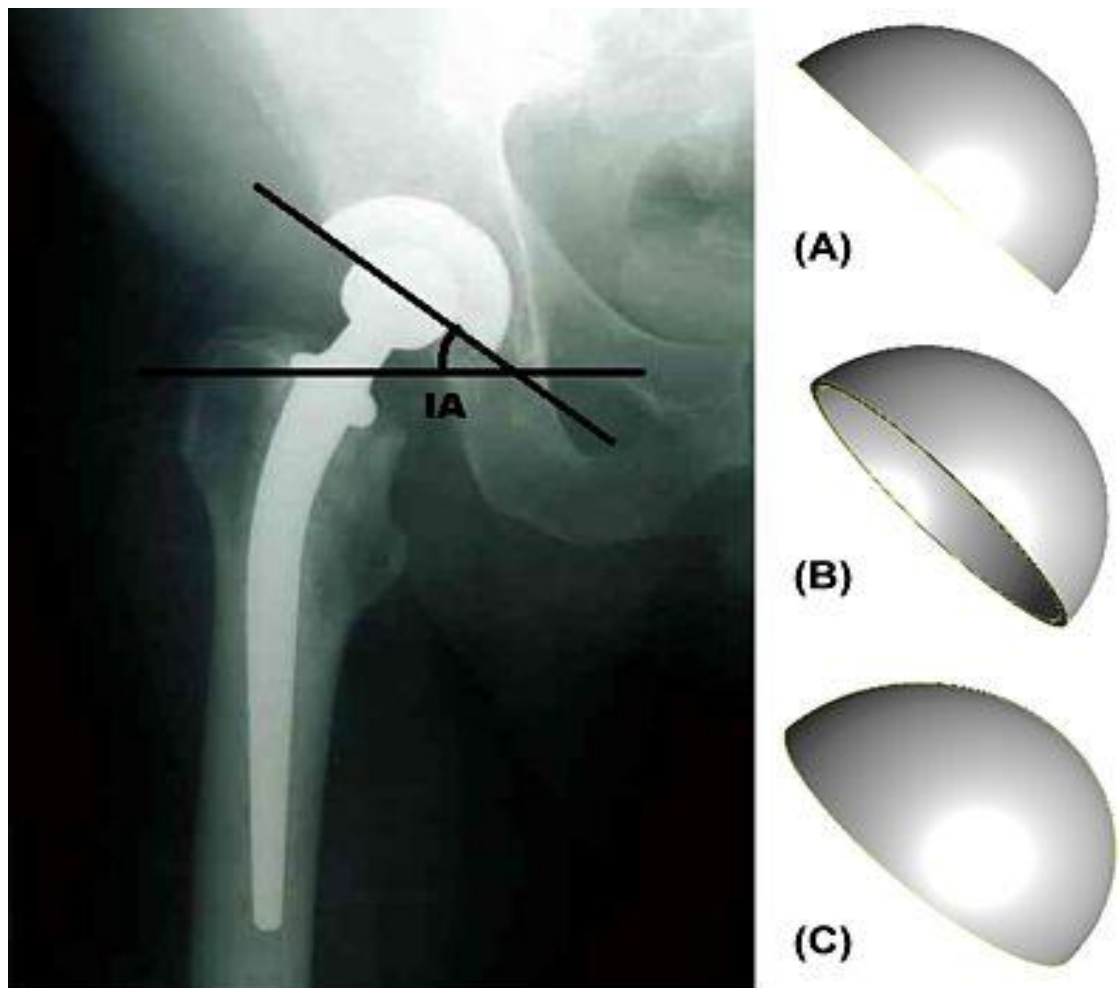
Left: Radiographic image of a right-side THR prosthesis, with the inclination angle (IA) marked. Right: Model of a right-side acetabular cup at 45° inclination and (A) 0° anteversion, (B) 10° retroversion (tilted towards the posterior), (C) 10° anteversion (tilted towards the anterior).
